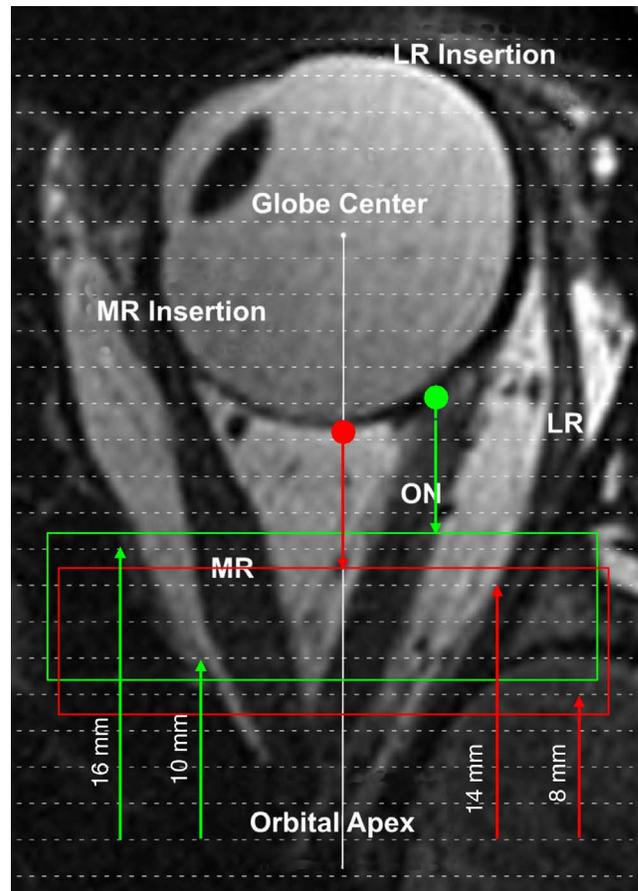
PPV sampling depends on eye position. For the adducted gaze pictured, the ROI (green box) referenced to the G-OJ (green dot) encloses four MRI slices (horizontal dashed lines, separated by 2 mm), located 10 to 16 mm anterior to the orbital apex. In central gaze, the G-OJ moves to the red dot and the ROI to the red box, sampling different parts of muscles and introducing a systematic gaze-related sampling error. Redrawn with permission from Clark and Demer.<sup>55</sup>
